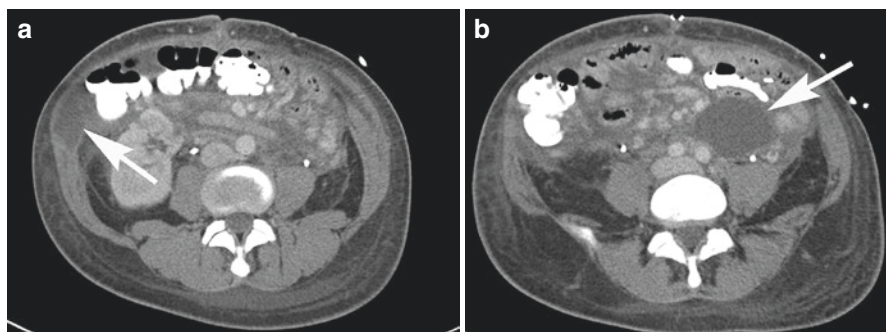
Postoperative abscesses in a man who developed fevers during the postoperative period after an en bloc small bowel, colon, and pancreas transplant performed short bowel syndrome after surgery for a desmoid tumor of the small bowel mesentery. Intravenous contrast-enhanced CT scans show loculated fluid collection in the right anterior abdominal wall (arrow in a) and posterior to the intestinal graft in the left abdomen (arrow in b). The transplanted bowel is normal in caliber and wall thickness. Edema is present in the small bowel mesentery and subcutaneous fat
